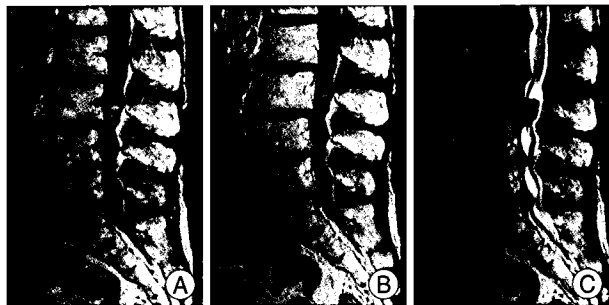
A mass of 14 × 10 mm in size compressing the spinal canal at a spinal level of L3. This mass shows heterogenous signal intensity on T2 (C)-, T1 (A)-weight image and T1-weighted with contrast enhancement images (B). A non-enhanced high signal, which is surrounded by a black hemosiderin ring (A).
